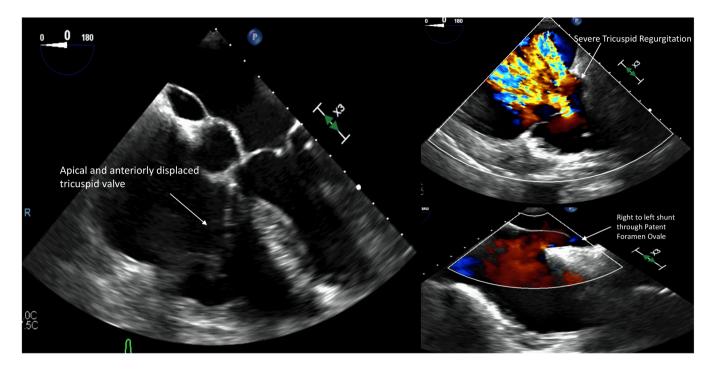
Transesophageal echocardiogram with color doppler showing structurally abnormal tricuspid valve, severe tricuspid regurgitation, and right-to-left shunt across a patent foramen ovale. [Color figure can be viewed at wileyonlinelibrary.com]
